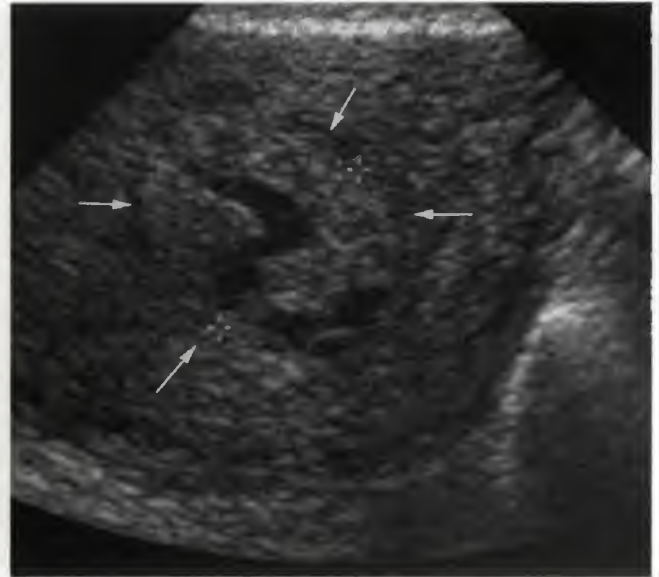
Longitudinal sonogram in a patient 3 days postpartum. Fluid and tissue (arrows) are seen in the uterine cavity. There was no evidence of retained products of conception.
